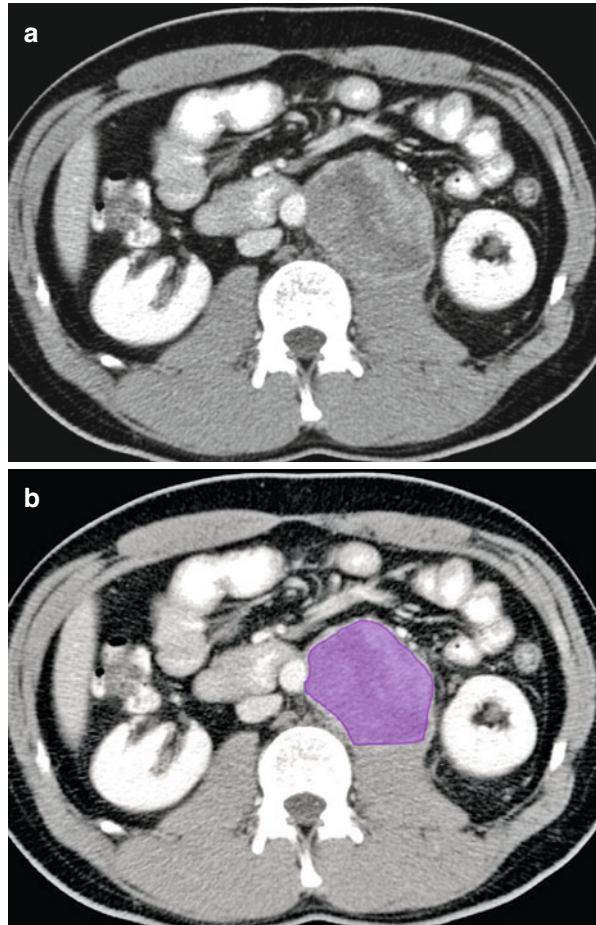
(a, b) Axial CT image shows metastatic right para-aortic lymph node (*red*) in a patient with testicular cancer
